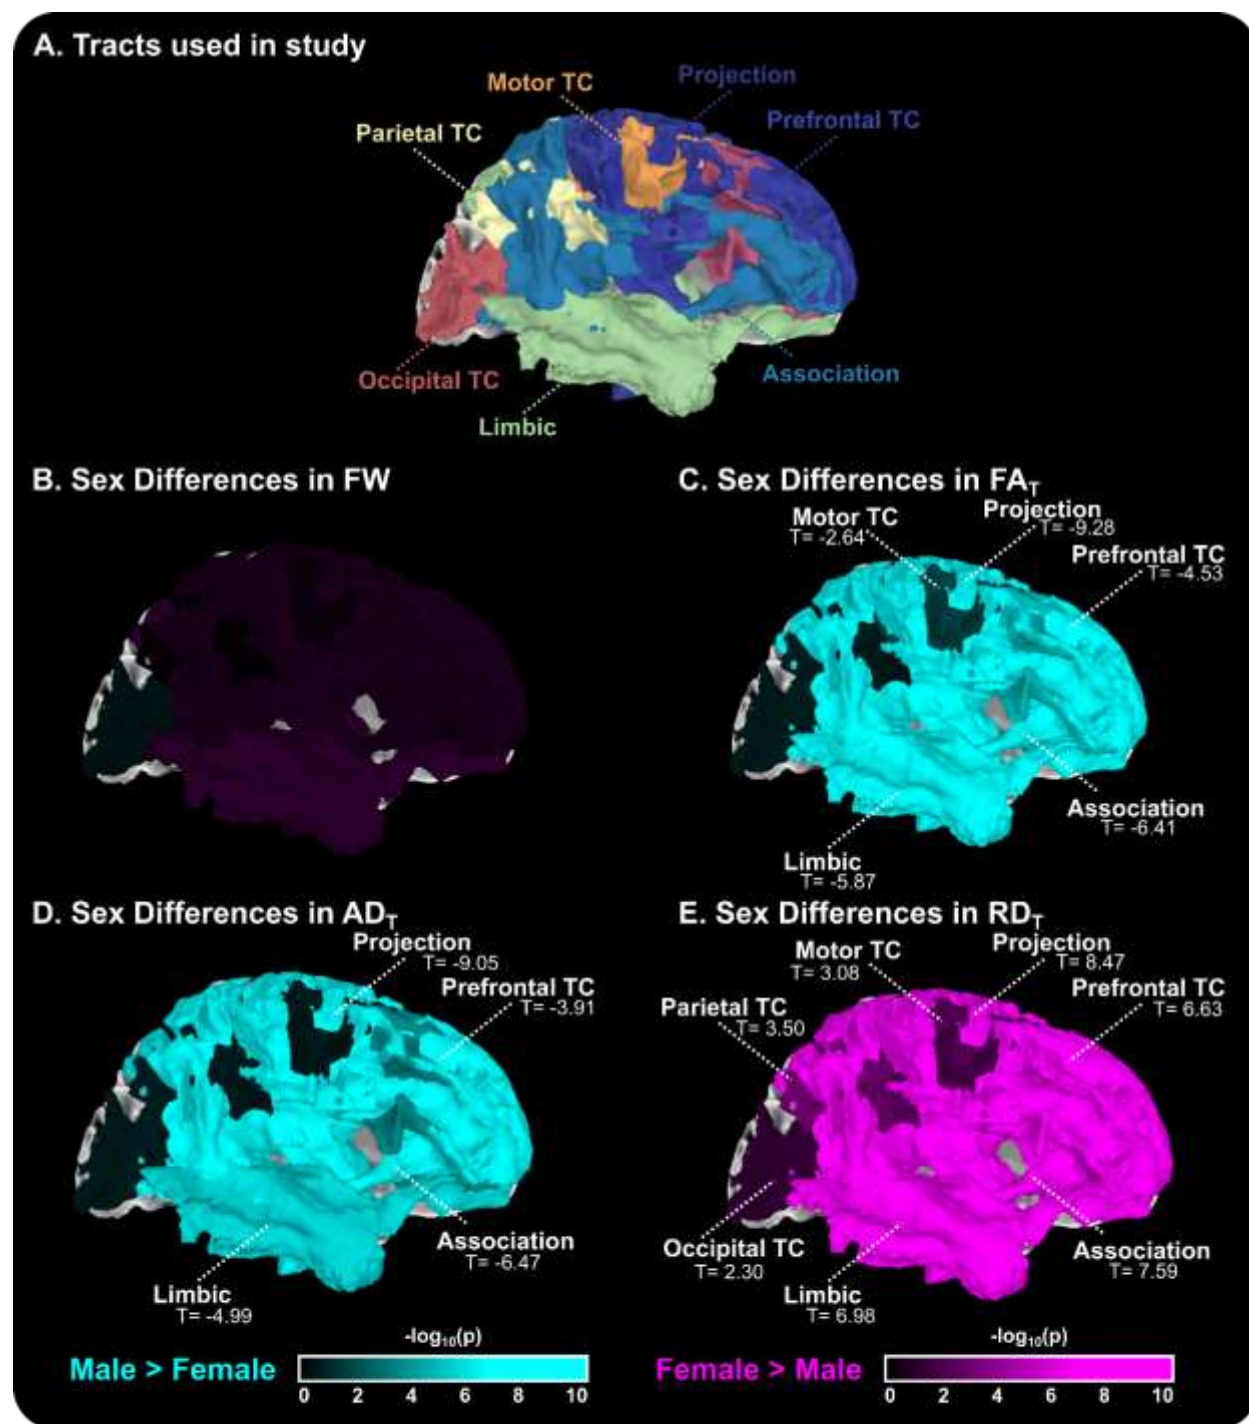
Using several white matter tract templates (A), this study used free-water diffusion MRI analysis to find that there no sex-specific differences in FW (B), but there are significant difference in FA_T (C), AD_T (D), and RD_T (E).
